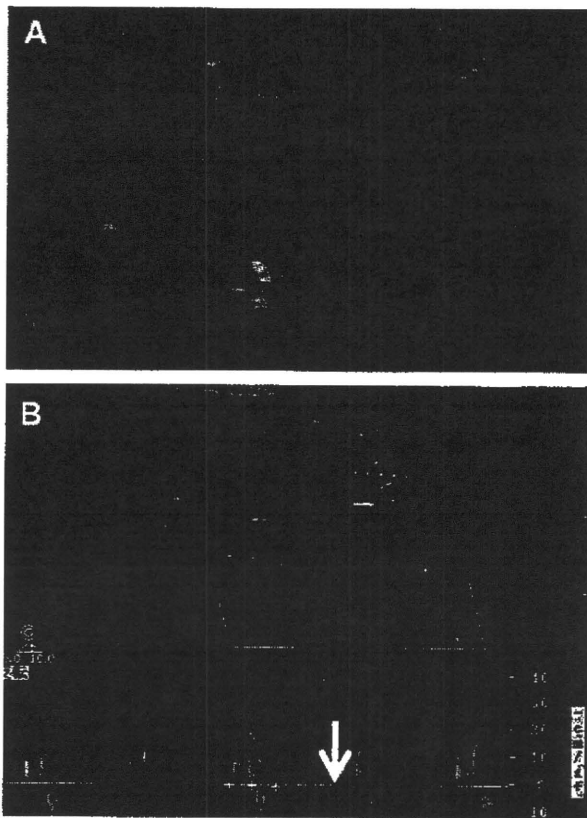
Typical carotid US findings in ICA occlusion. (A) Absent flow of color in the affected ICA origin in a patient with atherothrombotic extracranial ICA occlusion. (B) Absent end-diastolic flow velocity of affected ICA (arrow) detected by pulsed Doppler US in a patient with distal ICA occlusion.
